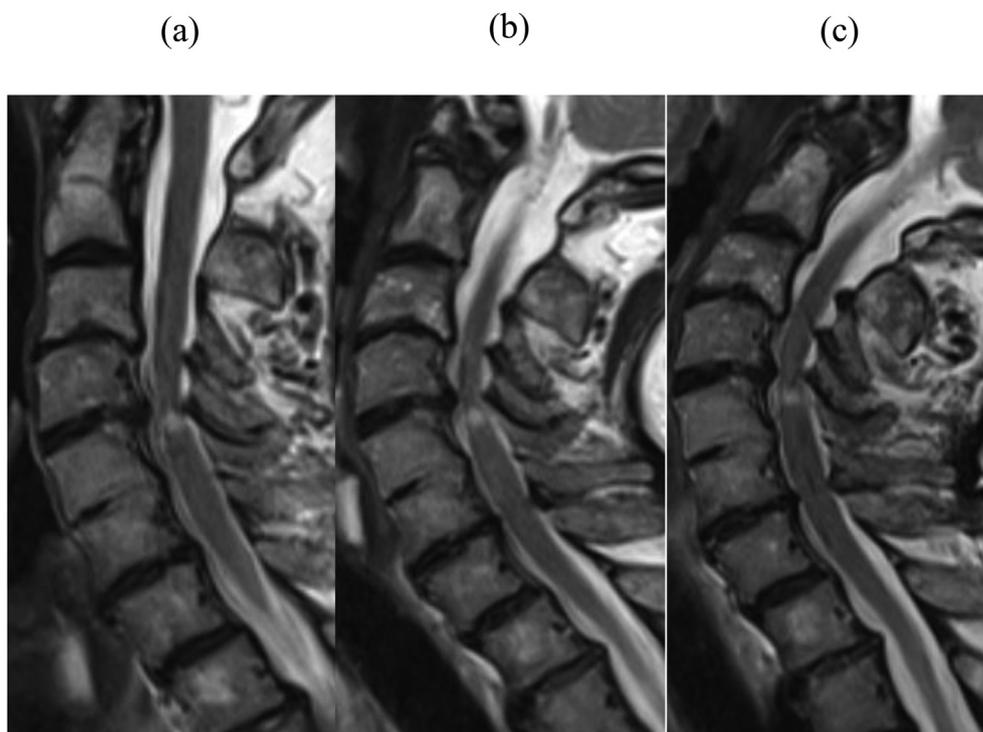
Increased signal intensity (ISI) was seen at the upper quarter level on magnetic resonance imaging at flexion position (a); however, it shifted more towards the caudal at neutral (b) and extension (c).
